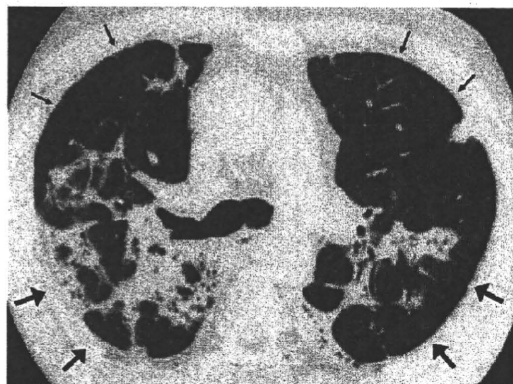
Nonspecific interstitial pneumonia (NSIP) associated with RA in a 63-year-old man. Transverse thin-section CT (2-mm collimation) at the level of tracheal carina demonstrates areas of air-space consolidation with traction bronchiectasis (large arrows) in a predominantly peribronchovascular distribution, and extensive diffusely distributed centrilobular nodules (small arrows).
